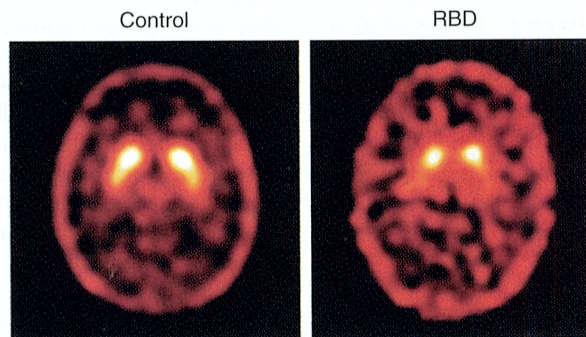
Dopaminergic function in rapid eye movement sleep behavior disorder (RBD) (^{123}I -(N)-(3-iodopropene-2-yl)-2beta-carbomethoxy-3beta-(4-chlorophenyl) tropane single-photon emission computed tomography). Dopamine transporter binding in one patient with RBD (*right*) and one control subject (*left*). Striatal binding was reduced on both sides in RBD, demonstrating a presynaptic dopamine deficit. Results were significant at $P < .05$. (From Eisensehr I, Linke R, Noachtar S, Schwarz J, Gildehaus FJ, Tatsch K. Reduced striatal dopamine transporters in idiopathic rapid eye movement sleep behaviour disorder: comparison with Parkinson's disease and controls. *Brain.* 2000;123[Pt 6]:1155-1160. Copyright 2000, with permission from Oxford University Press.)
